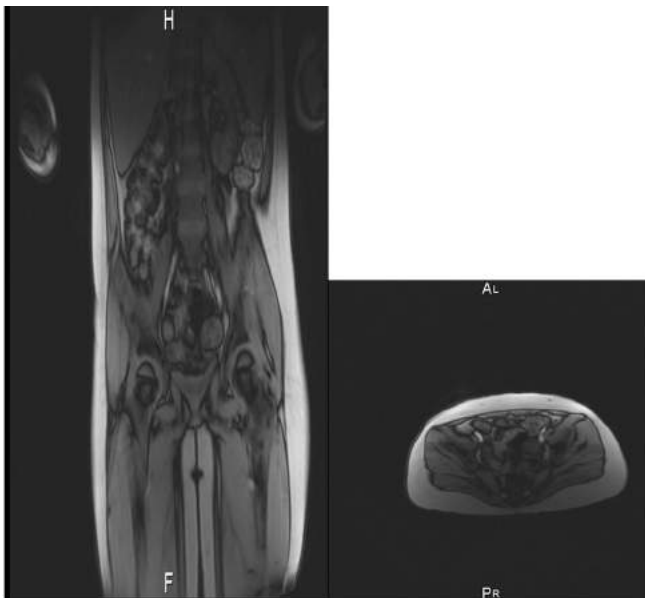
MRI showing the absence of uterus, ovaries and vagina.
